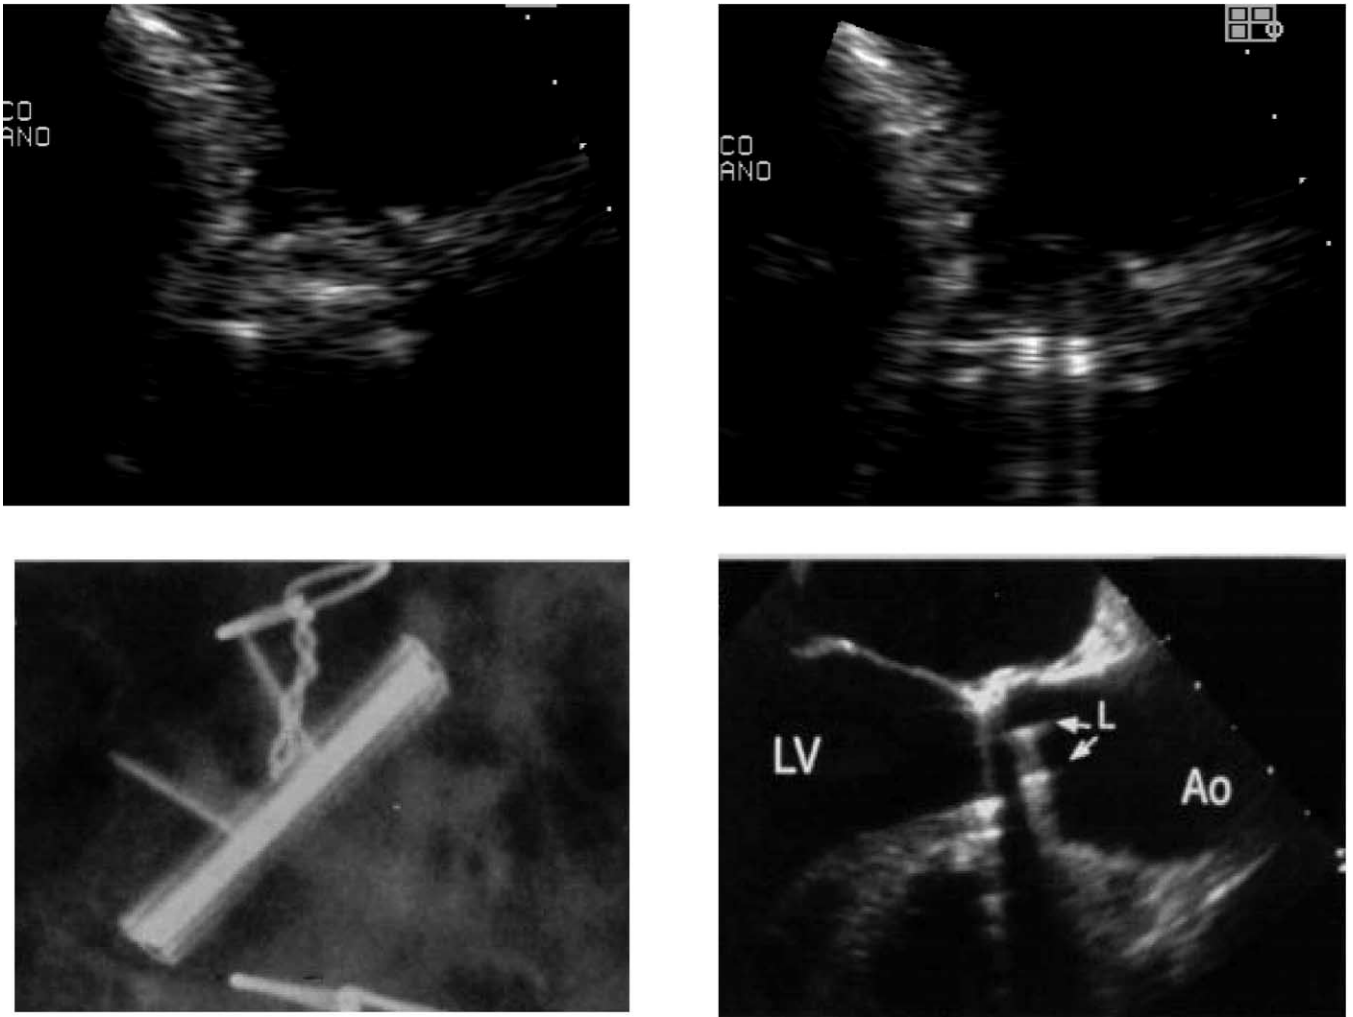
Normally functioning aortic bileaflet prosthesis. Closing angle and opening angle in apical 5-chamber transthoracic view (*top panels*), opening angle by cinefluoroscopy (*bottom left panel*) and by TEE long-axis view at 127° (*bottom right panel*). Ao = aorta; LV = left ventricle.
